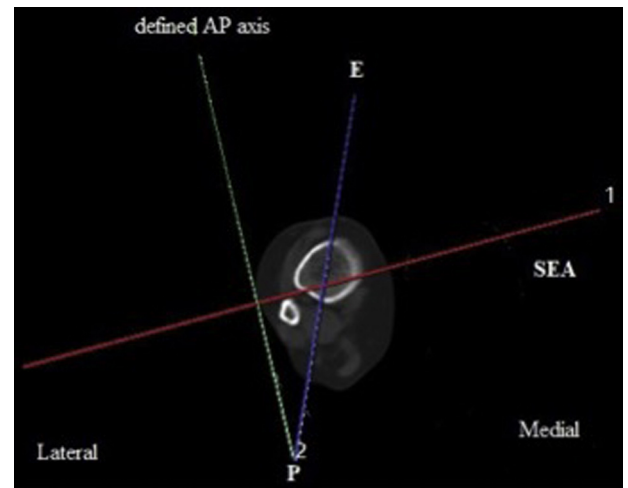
Axial CT image at the level of distal third of tibia in which angle E is the angle between the AP axis and the line connecting the most prominent point in the anterior border of tibia to PCL.
